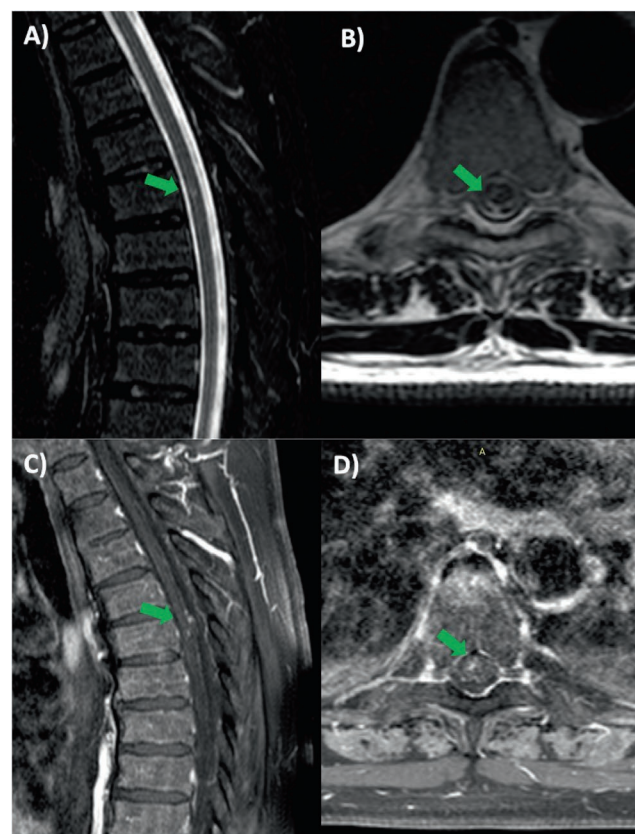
Lesion at T6 level on thoracic spinal cord MRI at first admission A. STIR, B. T2WI, C and D. T1WI with fat suppression after intravenous administration of contrast agent
